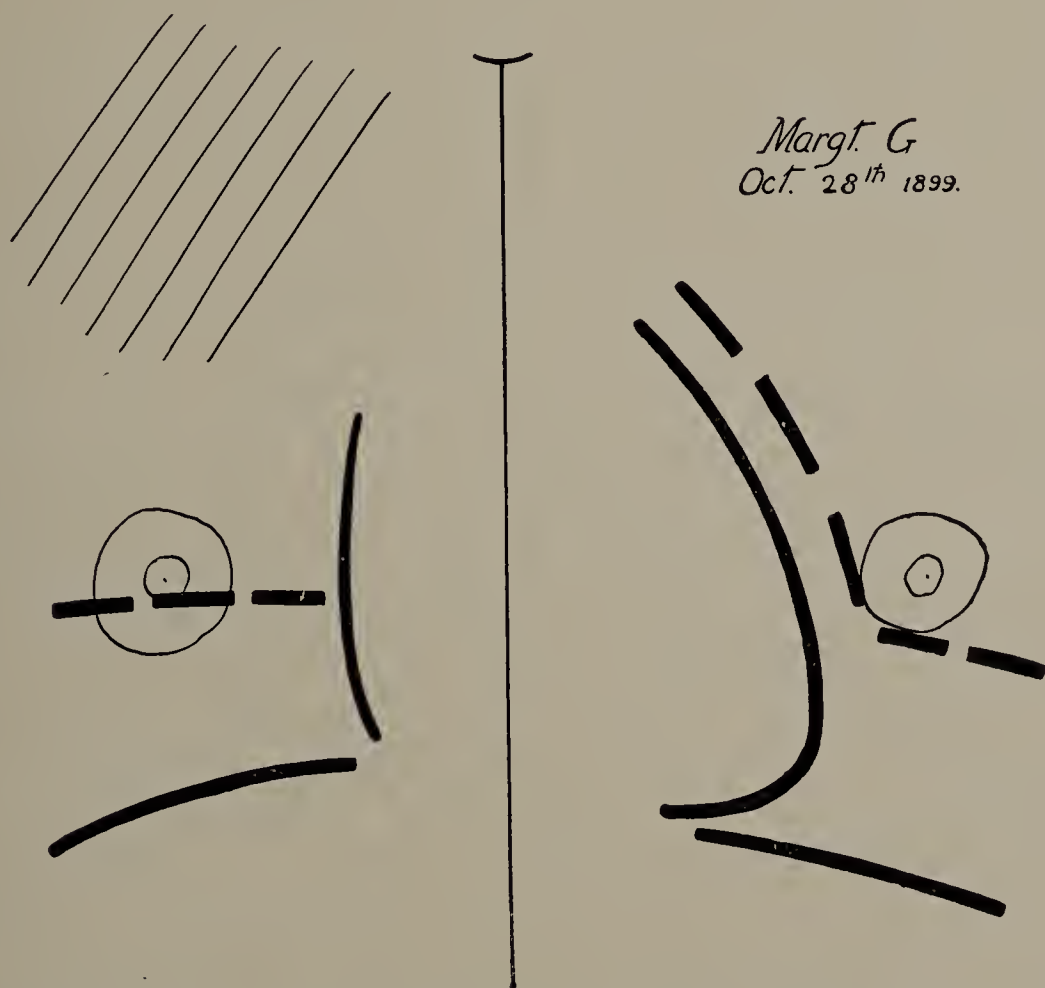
Margaret G. X-ray tracing made October 28, 1899. (One-third life size.) Right apex darker than normal; excursion of diaphragm shortened on right side.
